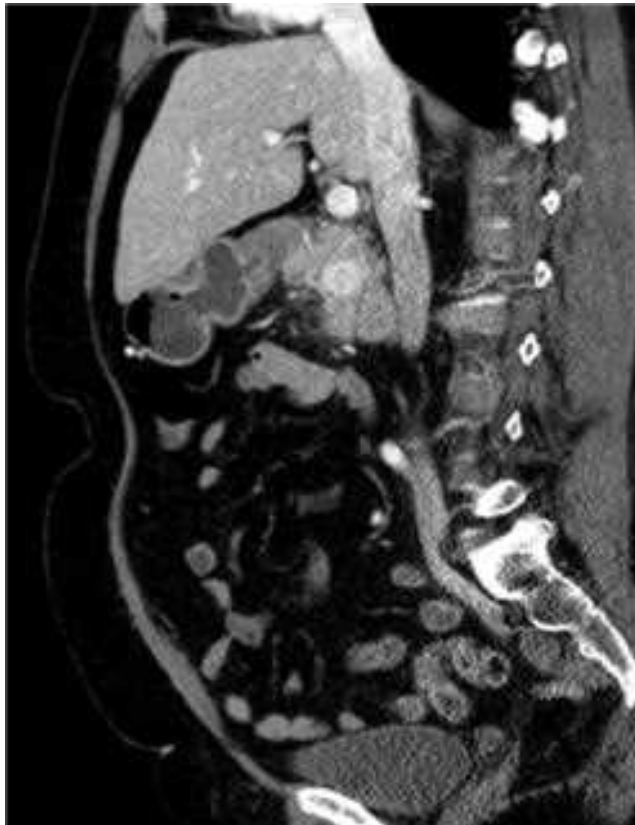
Pancreatic neuroendocrine tumor (PNET) demonstrating enhancement during arterial phase of CT scan. Pancreatic head PNET seen in (*left*) sagittal, (*middle*) coronal, and (*right*) lateral views of the abdomen.
